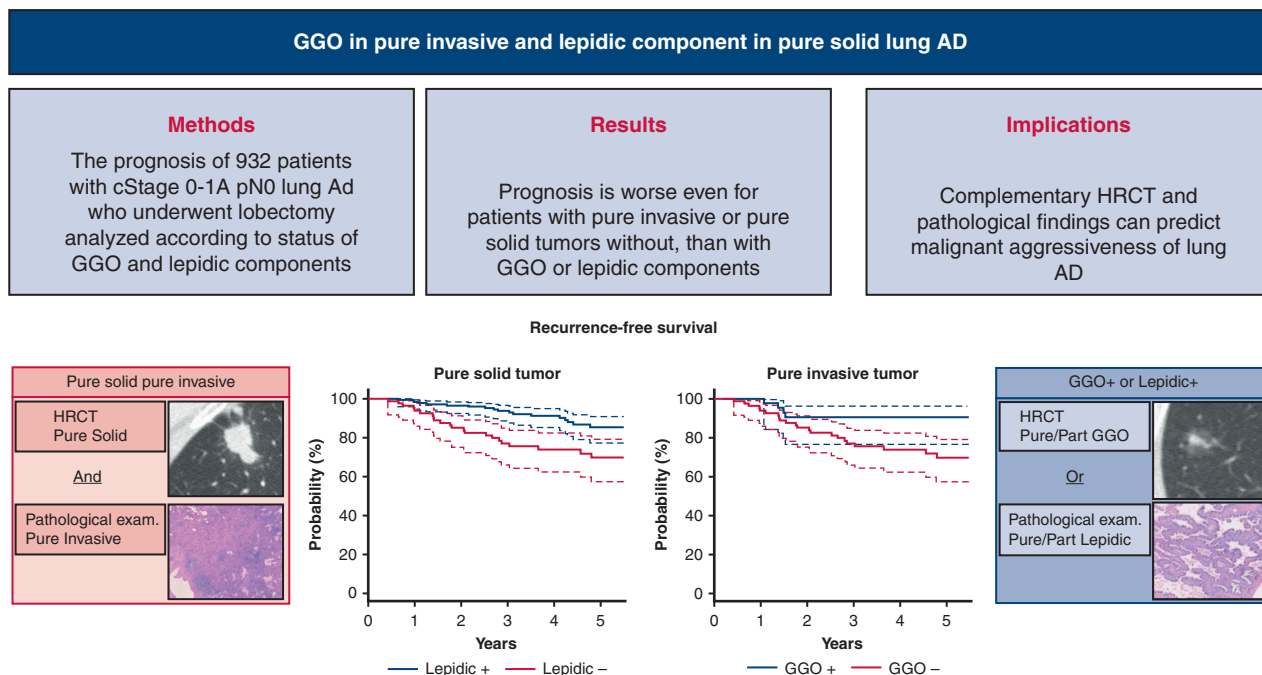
Recurrence-free survival is significantly worse for patients with pure solid tumors on high-resolution computed tomography without than with lepidic components and for those with postoperative pathologic findings of pure invasive tumors without, than with ground glass opacity components. GGO, Ground-glass opacity; AD, adenocarcinoma; cStage, clinical stage; pN0, pathological node negative; HRCT, high-resolution computed tomography.
